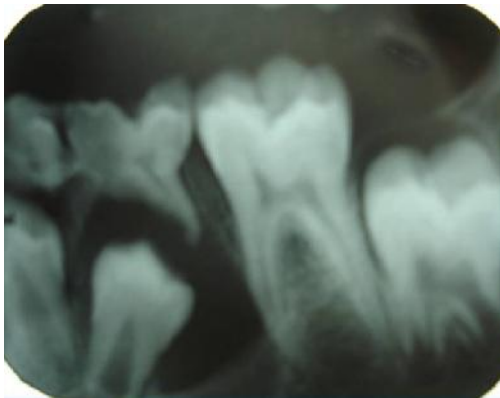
Pre Operative I.O.P.A. Radiograph showing well defined radiolucency surrounding crown of 35
